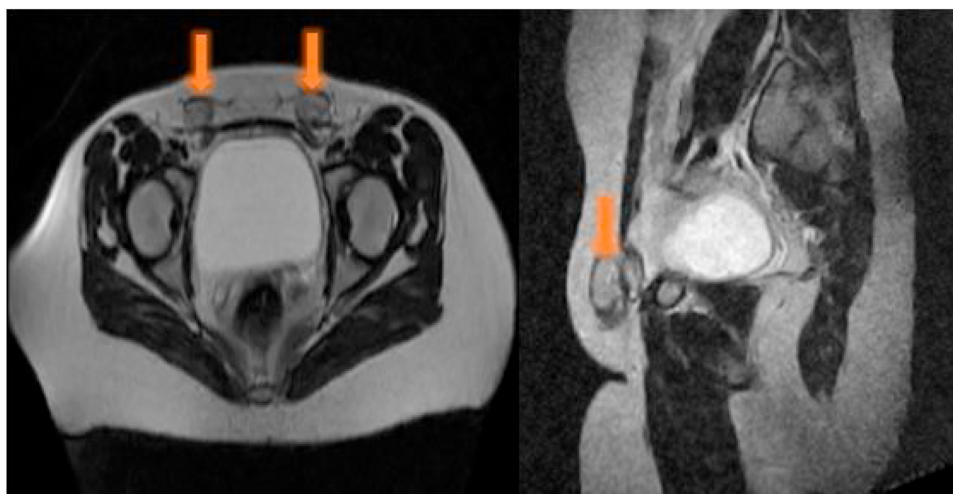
MRI ABDOMEN PELVIS t2 weighted showing the testicles annotated by orange arrow (axial and sagittal cuts) and complete absence of uterus, ovaries, cervix and internal vagina.
